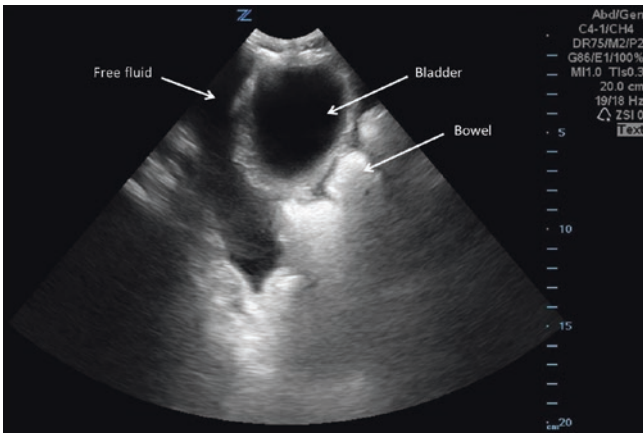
Ultrasound image of free fluid in the transverse plane of the pelvis. Pelvis with free fluid collecting in the rectovesical space. Image courtesy of Pimpa Limphan-udom
